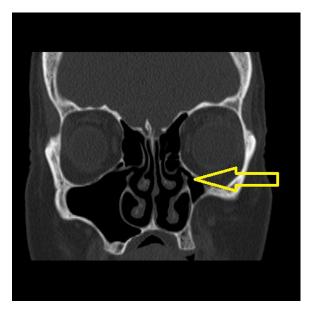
CT scan – silent sinus syndrome. Lateralization of uncinate process, maxillary sinus volume loss.
